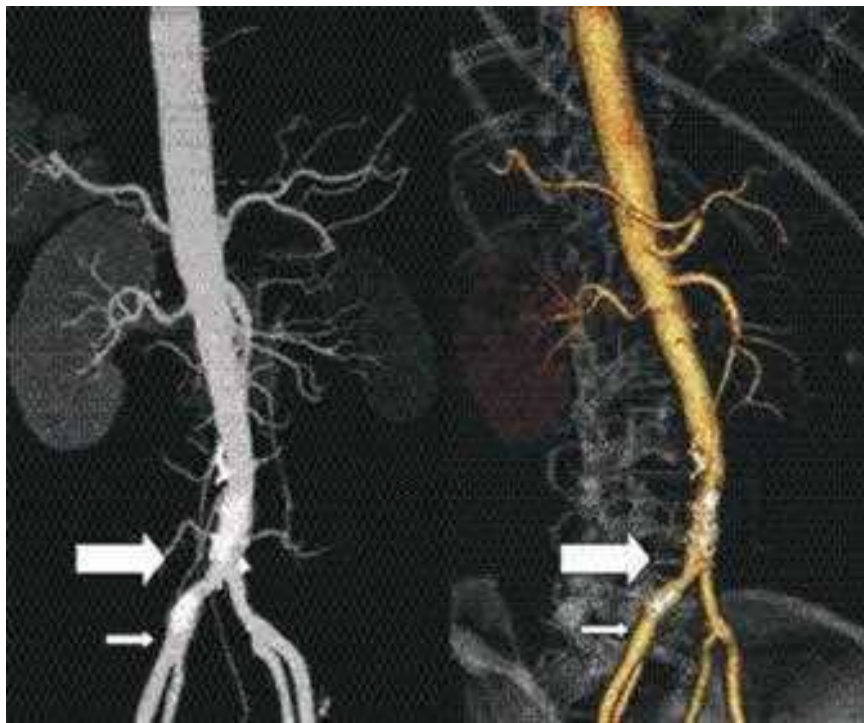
A. Multidetector computed tomography angiography of the aortoiliac artery circulation in a 63-year-old male with buttock claudication. B. Three-dimensional image reconstruction shows intra-arterial calcification of the aorta (*large arrow*) and right common iliac artery (*small arrow*). This is consistent with type I aortoiliac occlusive disease.
